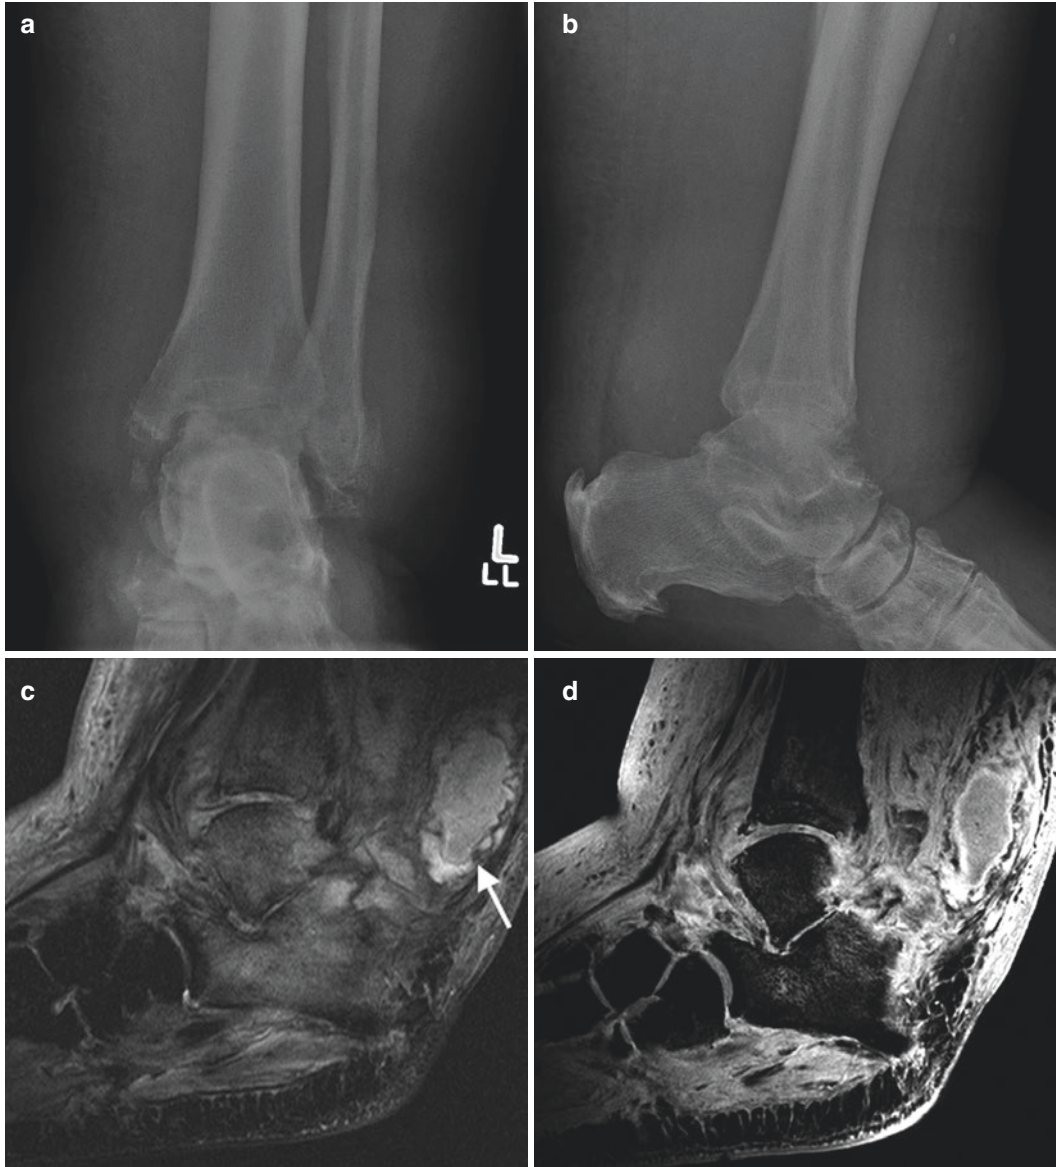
A 61-year-old male diabetic with osteomyelitis of the left ankle. (a) AP and (b) lateral radiographs demonstrate joint effusion, diffuse soft tissue swelling, joint space loss with central erosions and multiple chronic (well corticated) avulsed bone fragments. (c) Mid-Sag T2FS MRI with extensive bone marrow oedema in the tibia, talus and calcaneus and ankle joint effusion communicating with a large collection in Kager's fat pad
